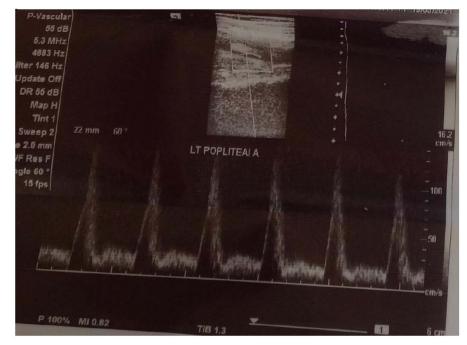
The arterial doppler showing peripheral artery disease with oedema of the lower left limb.
